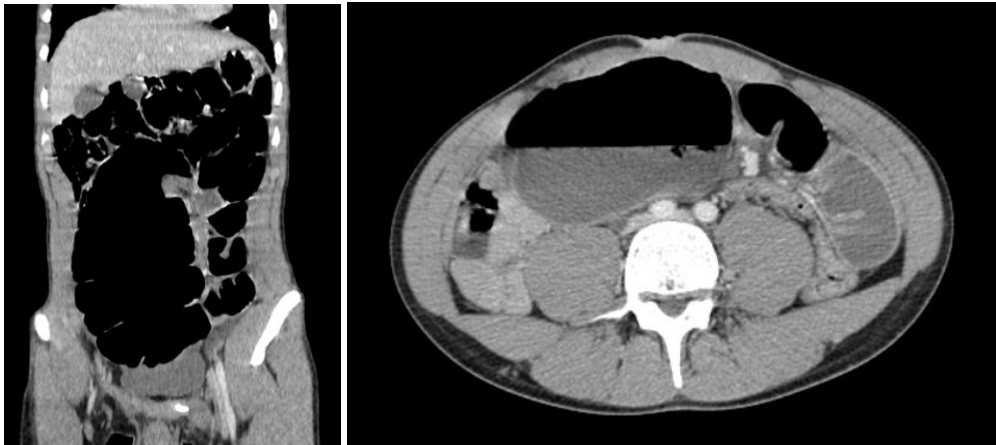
Contrast-enhanced abdominal CT. (A) Coronal reconstruction and (B) axial section showing marked distension of the cecum with dilatation of the small bowel and an absence of gas in the distal colon, consistent with a closed-loop obstruction
